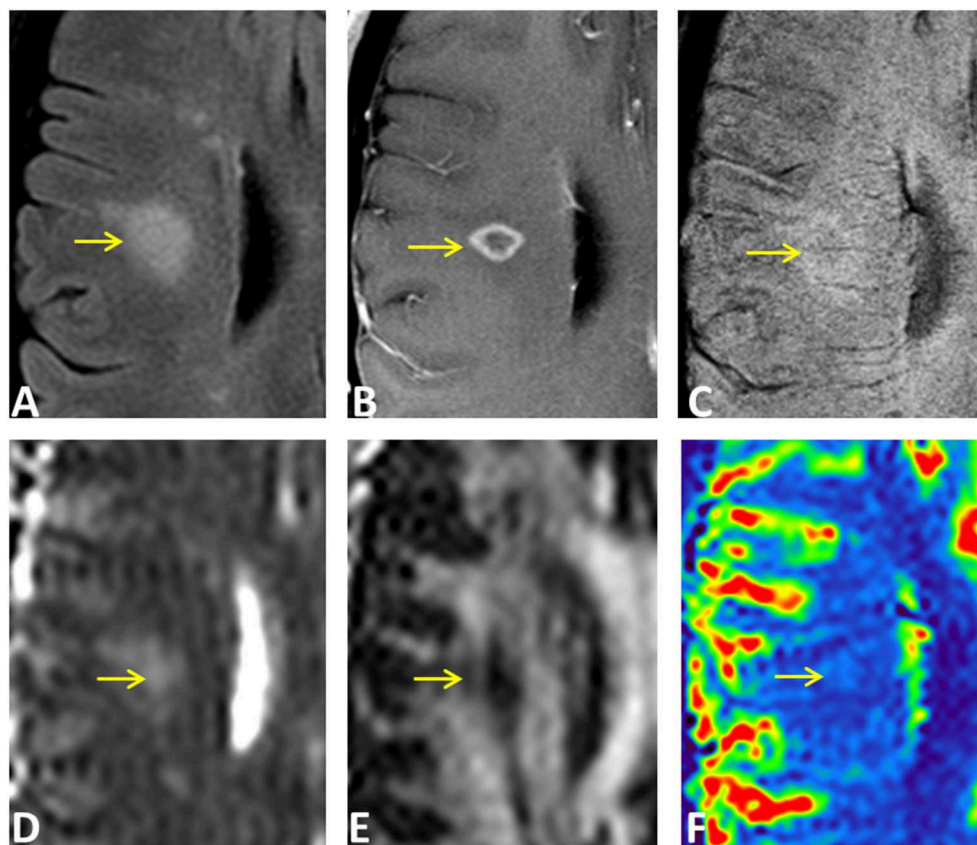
An ring-enhancing lesion in a 32-year-old female MS patient on FLAIR (A), Gd-enhanced T1-weighted (B), and SWI (C), as well as on MD (D), FA (E), and rCBF (F) parametric maps. The lesion has both Type-2 (isointense center on SWI) and Type-3 (hyperintense rim on SWI) components. The center of the lesion demonstrated larger MD changes compared to the enhancing rim that has increased perfusion of the entire lesion.
